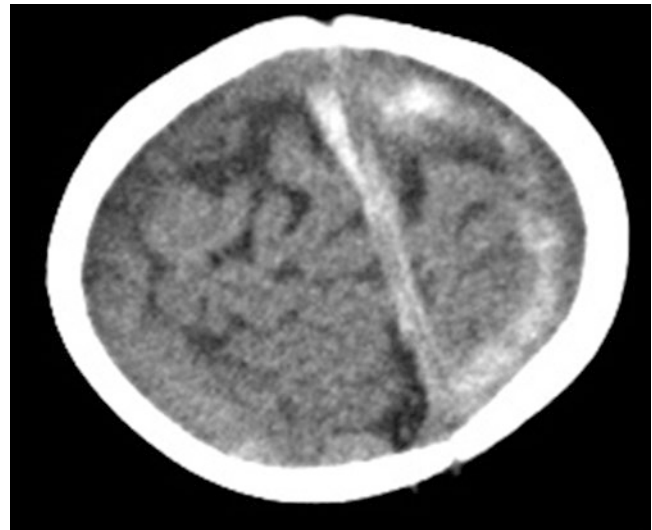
CT of brain. Note subdural hemorrhage extending into the interhemispheric fissure
